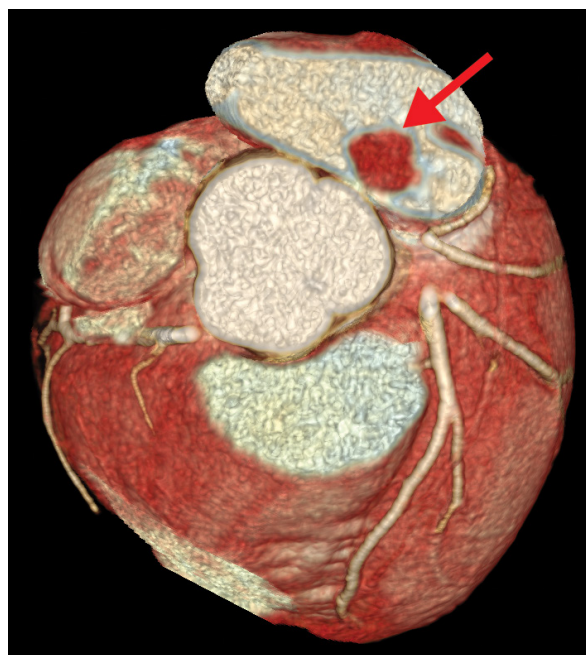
Computed tomography of the heart. A 1.5×2.1 cm tumour measuring (arrow) in the left atrium, at the interatrial septum
